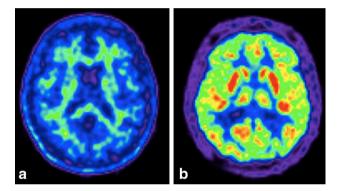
Example case of cognitively intact subject (55 years old, education: 5 years) with negative amyloid PET (a) and positive FDG PET (b). a amyloid PET shows no tracer uptake in cortical gray matter, but only aspecific uptake in white matter. b FDG PET shows hypometabolism in parietal lobes (particularly left parietal lobe), in posterior cingulate and precuneus, and in frontal lobes (particularly on the right side)
